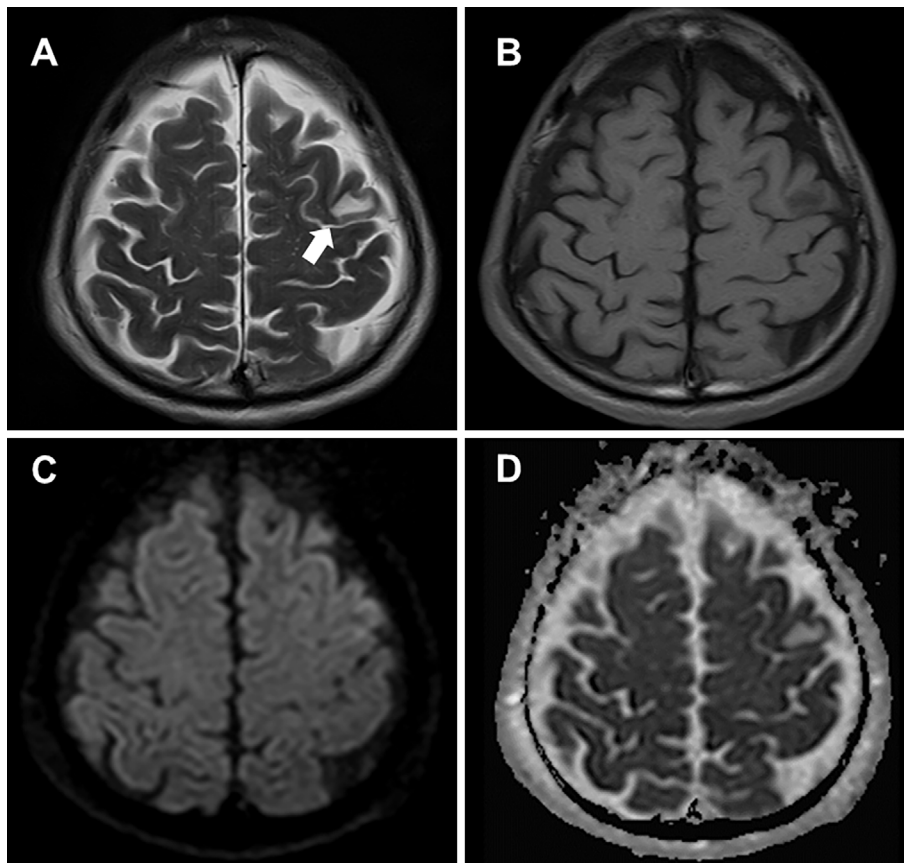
Brain MRI at admission. T2-weighted image (A) showing hyperintensity in the white matter of the left frontal subcortex (arrow). T1-weighted (B), diffusion-weighted (C), and apparent-diffusion-coefficient (D) images showing hypointensity and hyperintensity on the same lesion.
